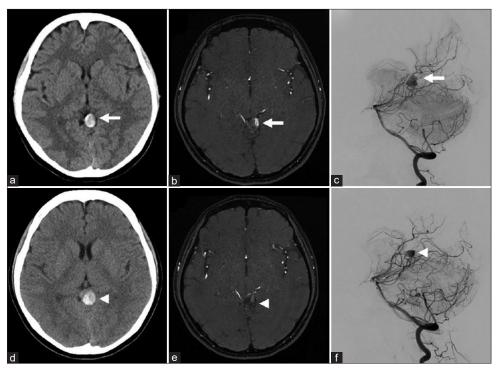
(a) Computed tomography (CT) showing a hyperdense lesion suspected to be a thrombosed aneurysm on the quadrigeminal cistern (arrow). (b) Magnetic resonance angiography (MRA) demonstrating partial blood flow in the aneurysm (arrow). (c) Left vertebral angiography image showing an aneurysm located in the P3 segment of the left posterior cerebral artery (arrow). (d) Enlargement of the aneurysm on CT (arrowhead). (e and f) MRA and left vertebral angiography showing decreased blood flow into the aneurysm compared to 1 month before (arrowheads).
